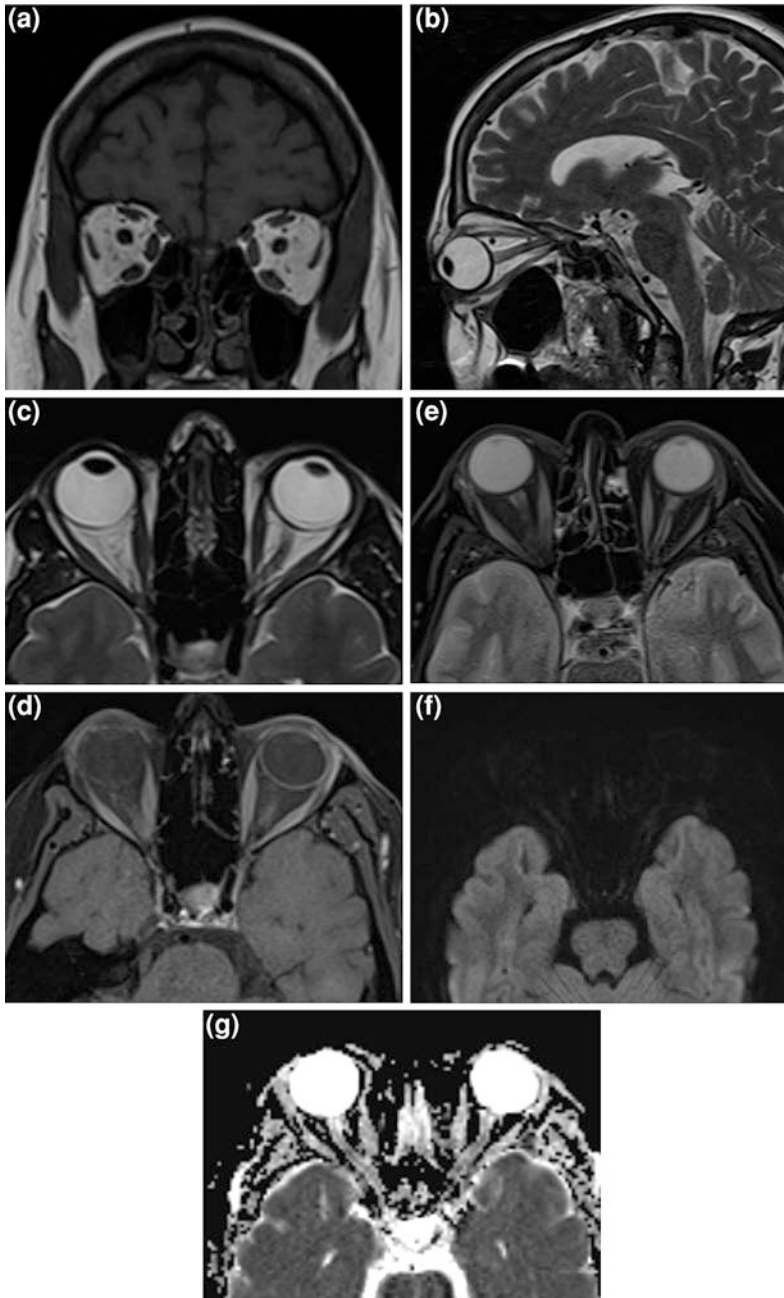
Normal orbit on MR imaging a Coronal T1 WI, b Sagittal T2 WI c–e axial T2WI, T2WI with fat suppression, post contrast T1WI with fat suppression MR images demonstrate normal signal intensity of the orbital fat and extraocular muscles f–g DWI and ADC map, DWI are obtained at b value of 0, 500 and 1000
